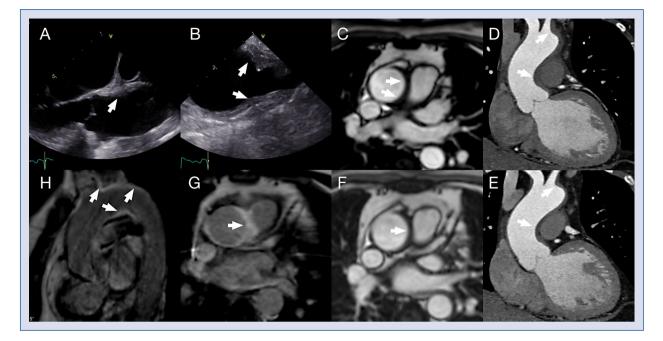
A. Transesophageal echocardiography, focal thickening of the ascendens aorta wall (arrows) before treatment; B. Transesophageal echocardiography, thickening of the wall of the aortic arch and proximal parts of its branches (arrows) before treatment; C. TrueFisp magnetic resonance examinations imaging of ascending aorta, note a semilunar thickening of the aortic wall before treatment (arrows); D. Mulitdetector computed tomography multiplanar reconstruction demonstrating a thickening of the wall of the ascending aorta and aortic arch before treatment; E. Mulitdetector computed tomography after treatment; F. TrueFisp magnetic resonance examination imaging after treatment; G. Delayed enhancement magnetic resonance examination imaging, note regions of the enhancement of the wall of the ascending aorta; H. Delayed enhancement magnetic resonance examinations imaging, note regions of the enhancement of the aortic arch and its branches.
